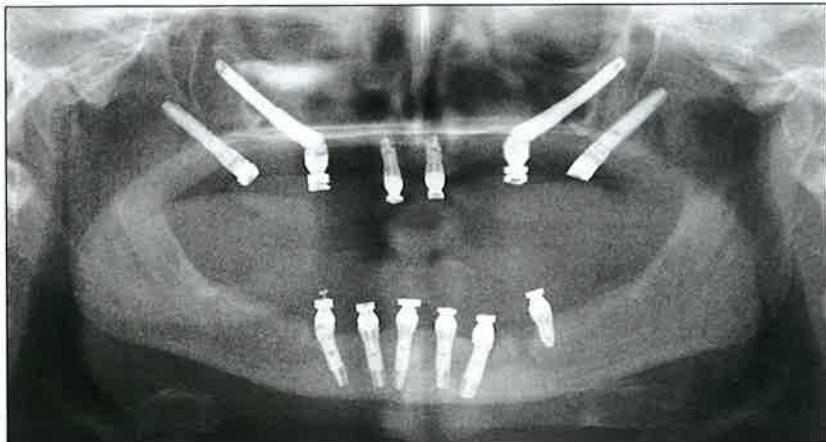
Postoperative panoramic radiograph obtained following delivery of the provisional acrylic resin prosthesis the day of implant placement.
